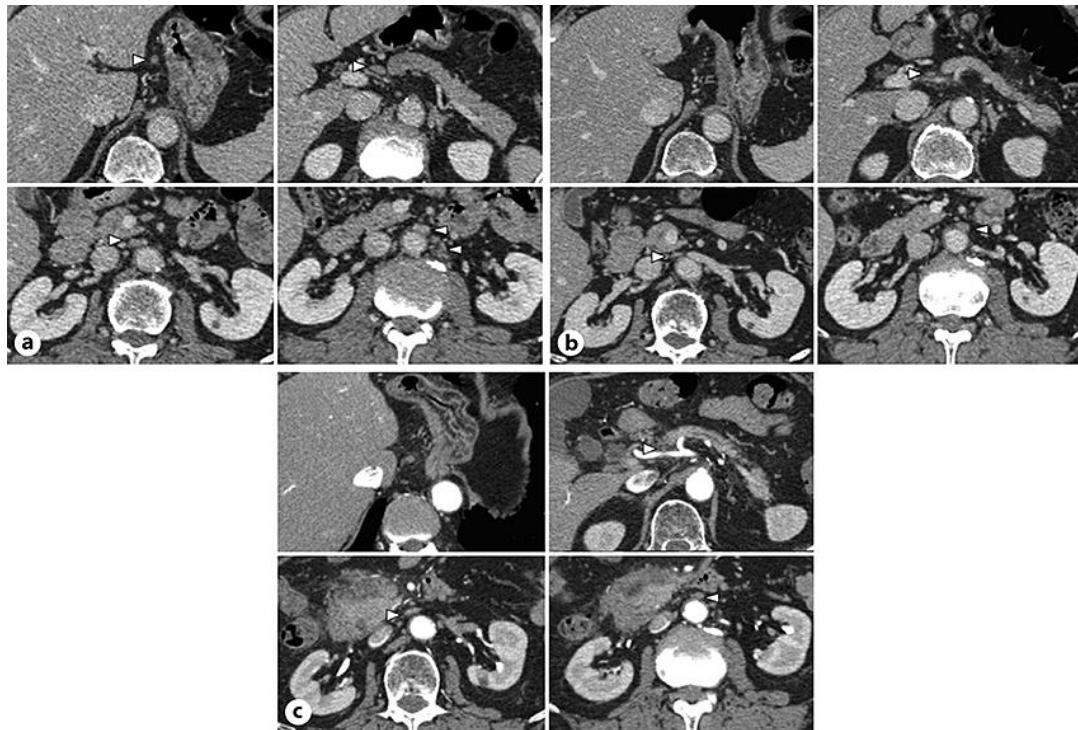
CT scan findings. a CT scan before treatment showed that lymph node (LN) swelling was detected in the lesser curvature LN, anterosuperior LN along the common hepatic artery, and para-aortic LN (white arrow). b After CRT, abdominal CT demonstrated marked reduction in LN size (white arrow), and LN of lesser curvature was not detected. c LNs have maintained the small size and showed no recurrences (37 months after first CT).
